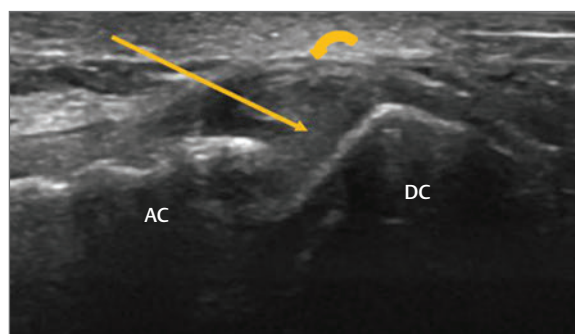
Ultrasound image of the acromioclavicular joint. The distal end of the clavicle (DC) may be seen to sit in a more superior position relative to the acromion (AC). This facilitates injection from the lateral aspect of the joint toward the lateral face of the clavicle (*straight arrow*). The curved arrow indicates the joint capsule.
